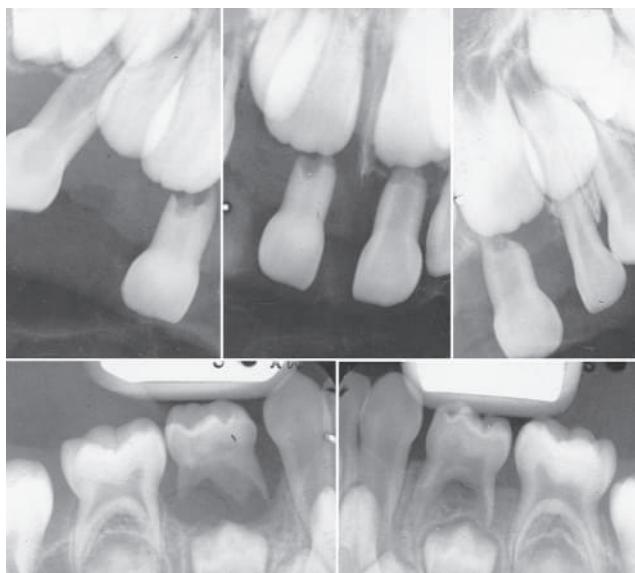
Radiographs of periodontitis in a 4½-year-old girl. A generalized loss of alveolar bone can be seen in the radiographs.
